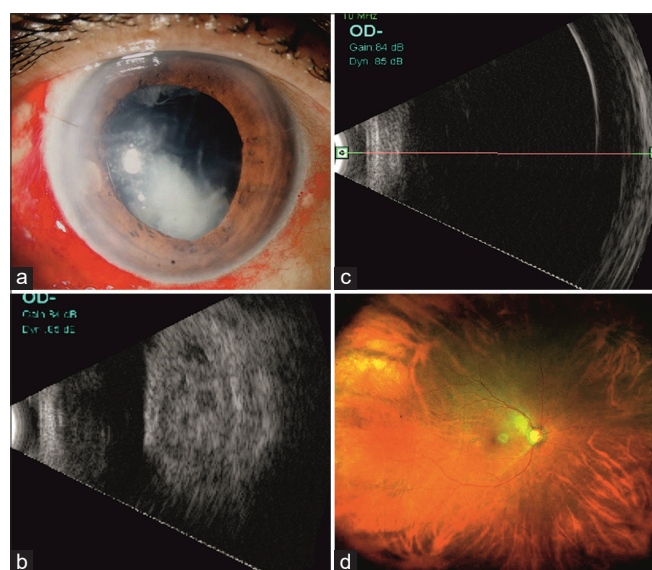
Shows (a) Pre-operative corneal edema, retained lens matters, and aphakia in Case I, (b) Pre-operative B-scan ultrasonography (USG) of the same patient showed suprachoroidal hemorrhage (SCH) in two quadrants, (c) Post-operative USG after two weeks showed completely resolved SCH under silicone oil, (d) Retina status after silicone oil removal
